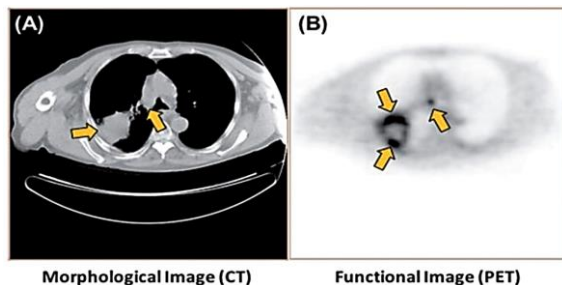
Hybrid PET/CT Combines Complementary Data: (a) CT Provides Detailed Anatomy without Function, (b) PET Displays Tracer Uptake, but it Lacks Structural Information.
